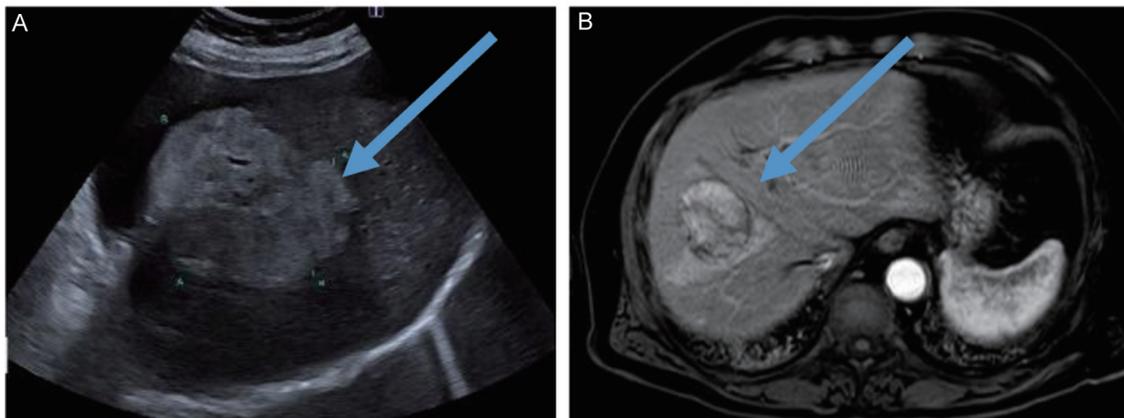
Examples of surveillance failure. (A) Ultrasound (US) with HCC detected outside the Milan criteria after previous negative US. (B) Magnet resonance imaging (MRI) with HCC detected outside Milan criteria that was not seen on US.
